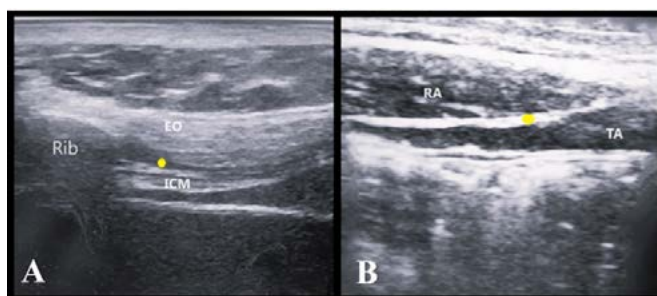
Ultrasound imaging of (A) external oblique intercostal plane and (B) subcostal transversus abdominis plane; yellow dot indicates the site of local anaesthetic injection
